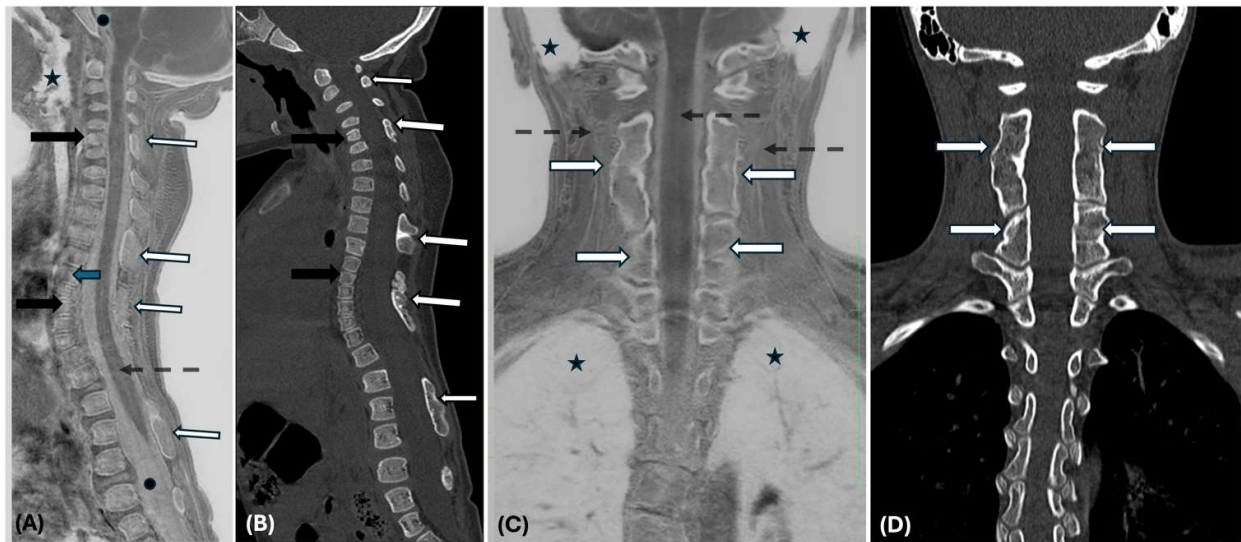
(A) Sagittal CS-FRACTURE MR and (B) CT bone window images of the whole spine of a 2-year-old with Klippel Feil (KF) anomaly show multilevel partial fusion of the cervical and thoracic vertebral bodies (black arrows) and fusion of posterior elements (white arrows). The bone details are well seen on the FRACTURE MRI, but lack of cortical maturation can be seen on images of both the modalities. There are artefacts along the fused lower thoracic vertebrae from adjacent cardiac motion (white arrowhead in a). (C) Coronal CS-FRACTURE MR and (D) CT bone window image of a 13-year-old with KF anomaly show fusion of multiple cervical vertebrae and their posterior elements (white arrows). Also note various normal signal intensities, very bright signal of air in the upper airway, lungs and mastoid air cells (black star in A and C respectively). CSF in the thecal space appears less bright than air (black dot in A), cord and other paraspinal soft tissues appear grey (dotted black arrows in A and C).
